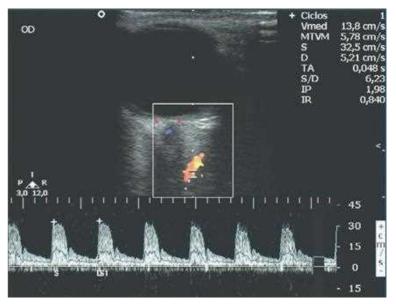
Color Doppler Image of the Ophthalmic Artery. The Doppler-shifted spectrum (time–velocity curve) is displayed at the bottom of the image. Red pixels represent blood movement toward to the transducer.
